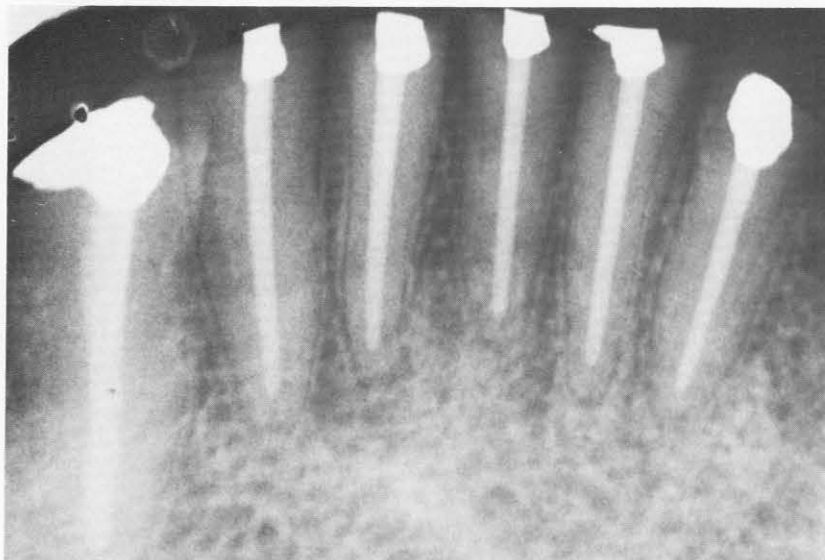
Followup radiograph, 3 years, 2 months
